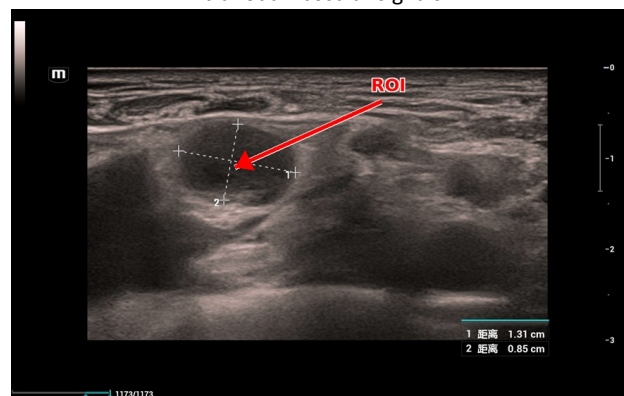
Representative grayscale ultrasound image of a small suspicious lymph node. The arrow indicates the measured target ROI.
